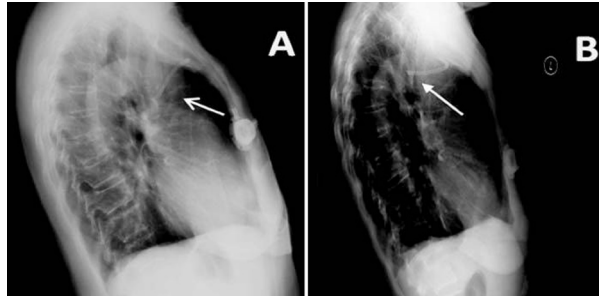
64-year-old woman with implanted venous access device. A, Lateral chest radiograph after initial catheter placement; B, Lateral chest radiograph 8 months later shows that the tip of the catheter has migrated.
